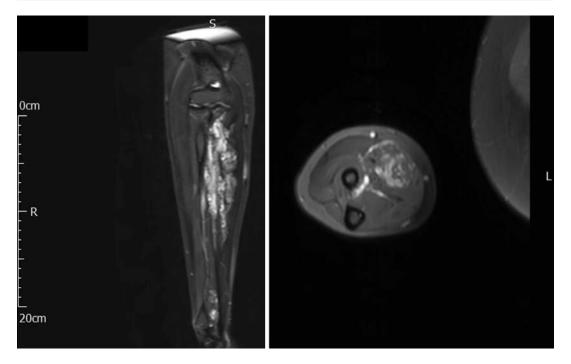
MRI with Coronal STIR and Axial T1 weighted images of a low-flow venous malformation showing Typical high signal and enhancing venous spaces
